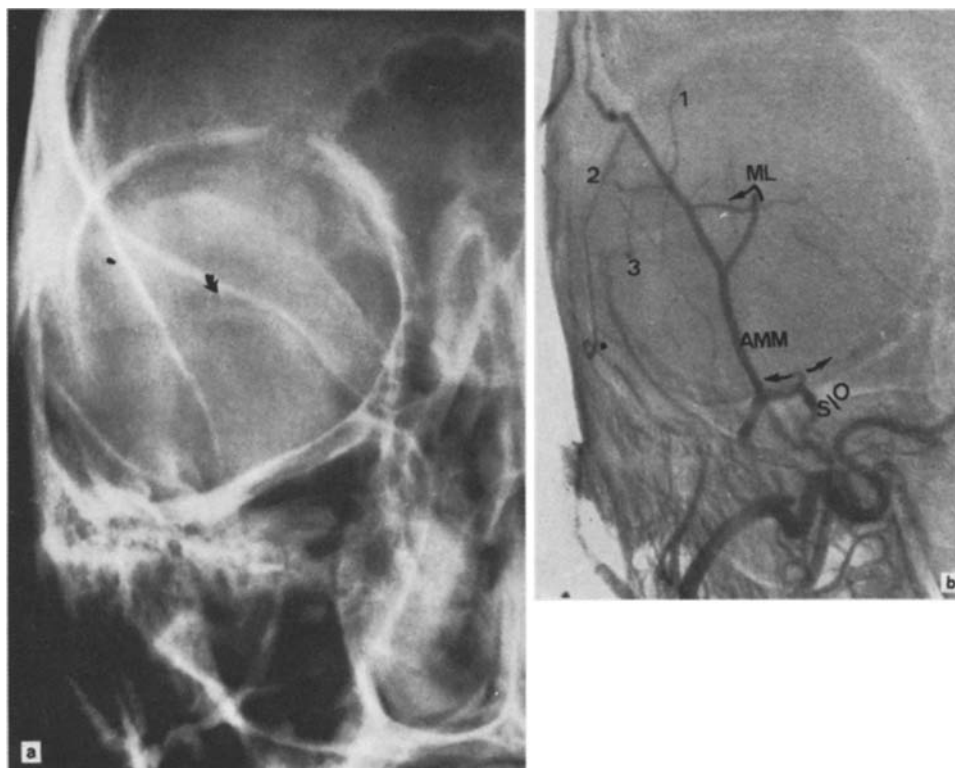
a. Frontal radiograph of the orbit. Note the canal of Hyrtl (meningolacrimal foramen) just lateral to the superior orbital fissure (arrow). b. Frontal view of a selective external carotid angiogram. Note the meningo-lacrimal (ML) branch of the middle meningeal artery (AMM) and its branches: 1) glandular ramus; 2) glandular-palpebral ramus; 3) muscular-anastomotic ramus. The lateral branch (*) of the orbital ramus issued from the suborbital artery (S/O) is also well visualized
